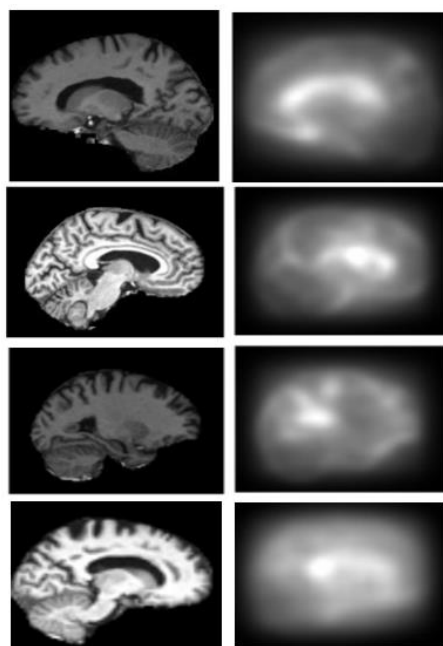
Saliency maps of normal subjects' MRI images.
